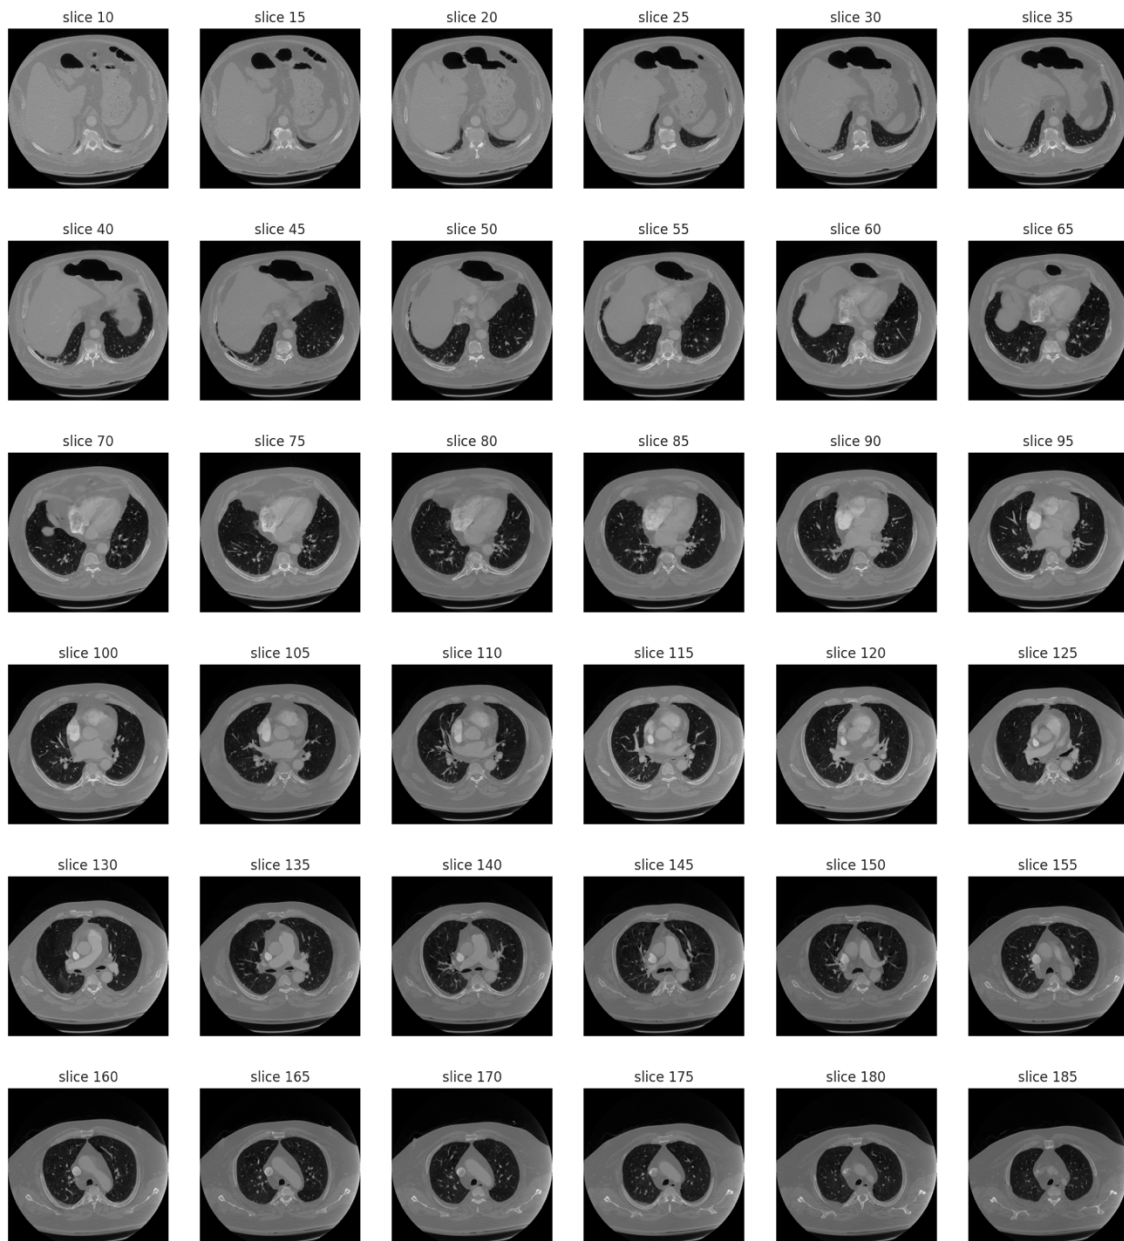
Sequence of axial thoracic CT slices for a single patient, displayed at intervals of 5 slices each.
